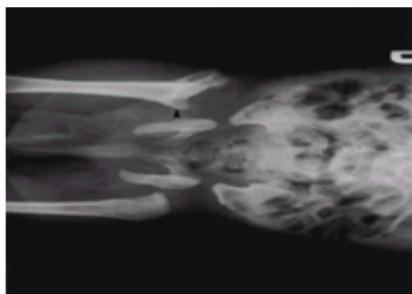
Septic arthritis in a 4-month-old baby with dislocation of the left hip. Radiograph shows lateral displacement of the femoral head and new bone formation.
